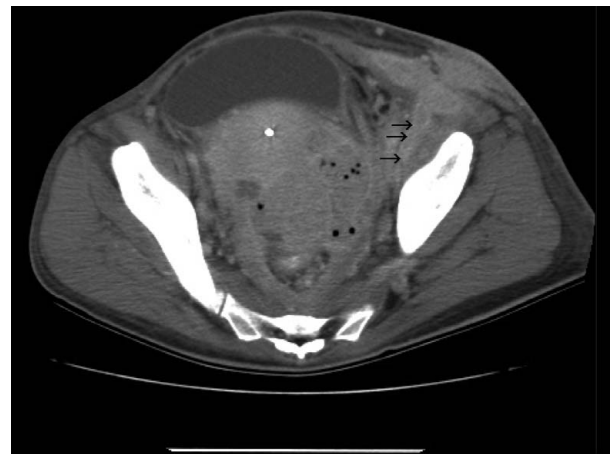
Computed tomography scan. The arrows indicate the fistula tract towards the left lower abdominal wall.
